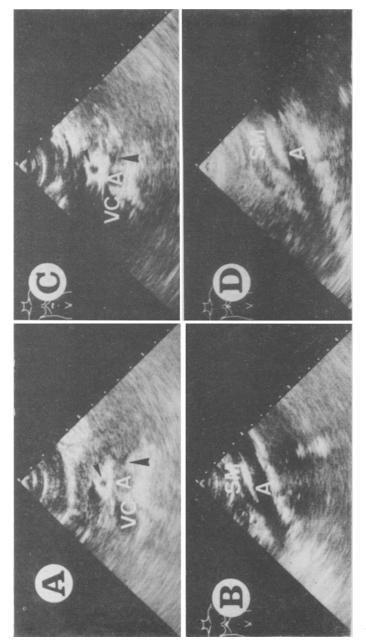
A and B are ultrasound images of the abdomen during haematuria, C and D at normal urination. A and C: Transverse supine view. B and D: Longitudinal section. Comparing A with C, and B with D, respectively, the space between the superior mesenteric artery and the aorta during haematuria is smaller than that at normal urine. VC: inferior vena cava, A: aorta, SM: superior mesenteric artery, large arrowhead: left renal vein; small arrowhead: superior mesenteric artery
